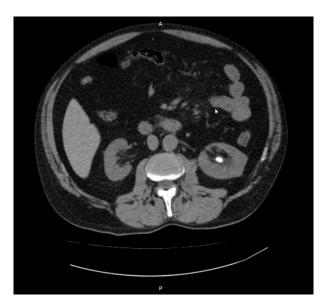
Computed tomogram of the potential donor. Native phase. Stone in the medial calyx of the left kidney
